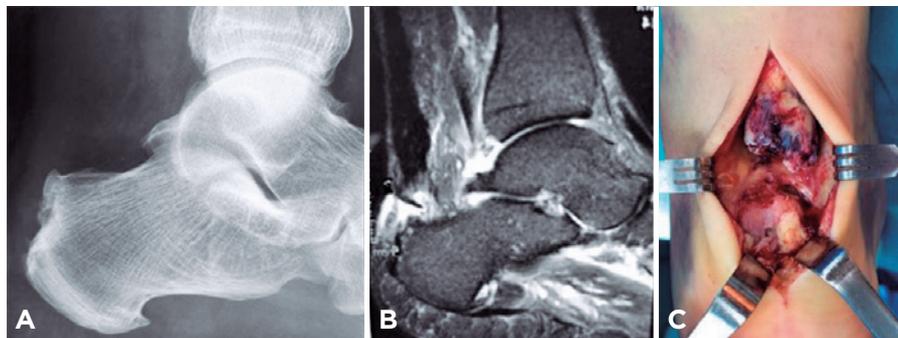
(A) X-ray showing Haglund exostosis and irregularity in the insertion area. (B) T2-weighted MRI, sagittal view, showing complete detachment of Achilles insertion. (C) Clinical view.
